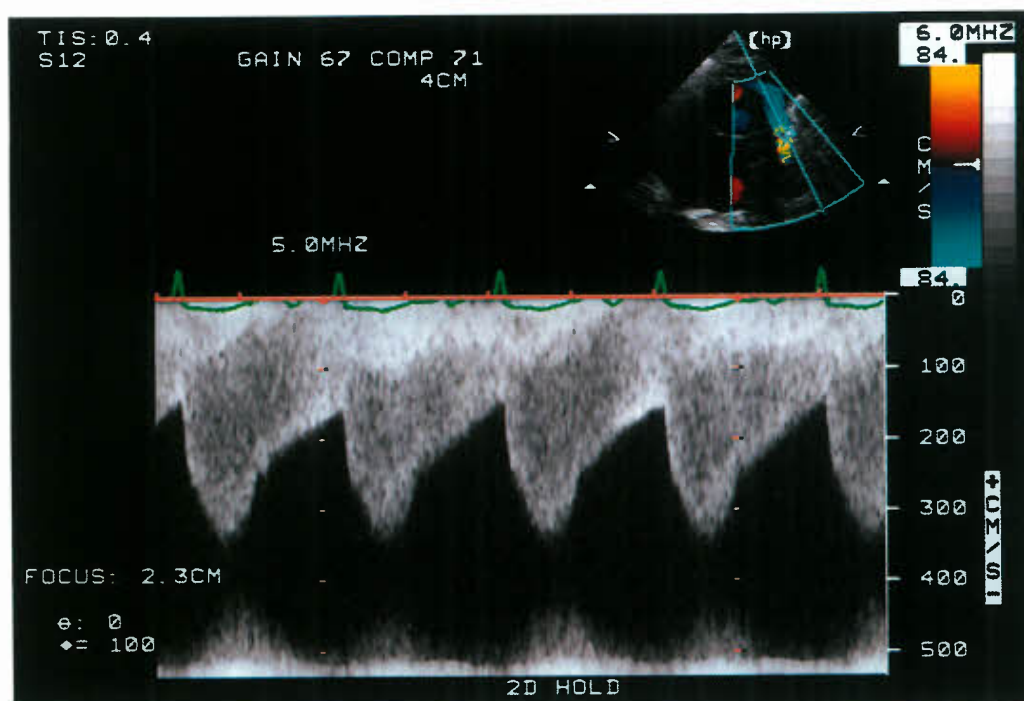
Typical continuous-wave Doppler display across a severe coarctation. The peak velocity is 3.4 m/s. Note the diastolic runoff pattern consistent with a pressure gradient throughout diastole.
